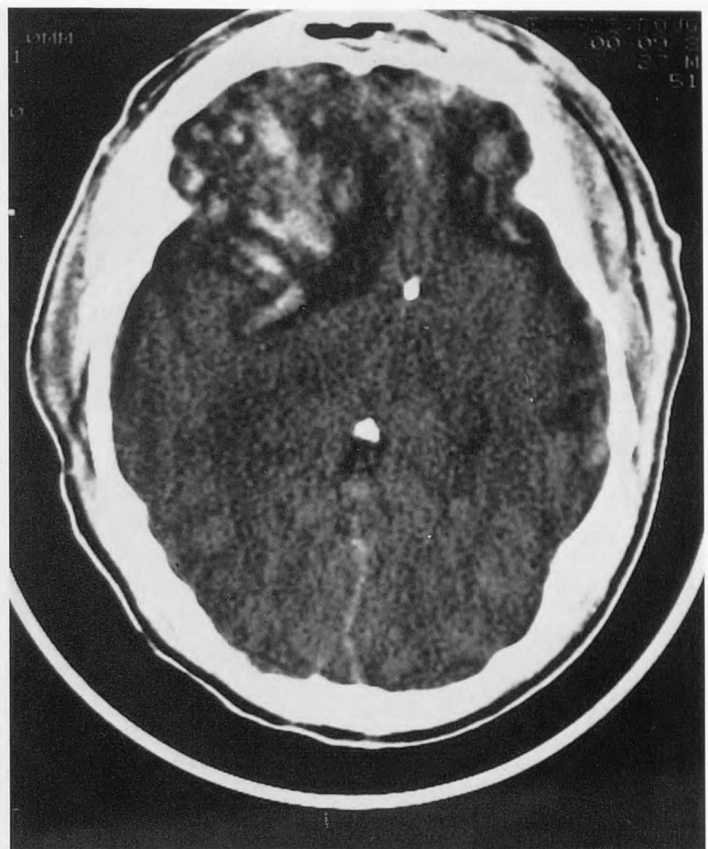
CT scan in a patient with bifrontal (right greater than left) hemorrhagic contusions. This patient presented in a coma after an acceleration-deceleration injury and did not undergo surgery but instead was managed for increased intracranial pressure.
